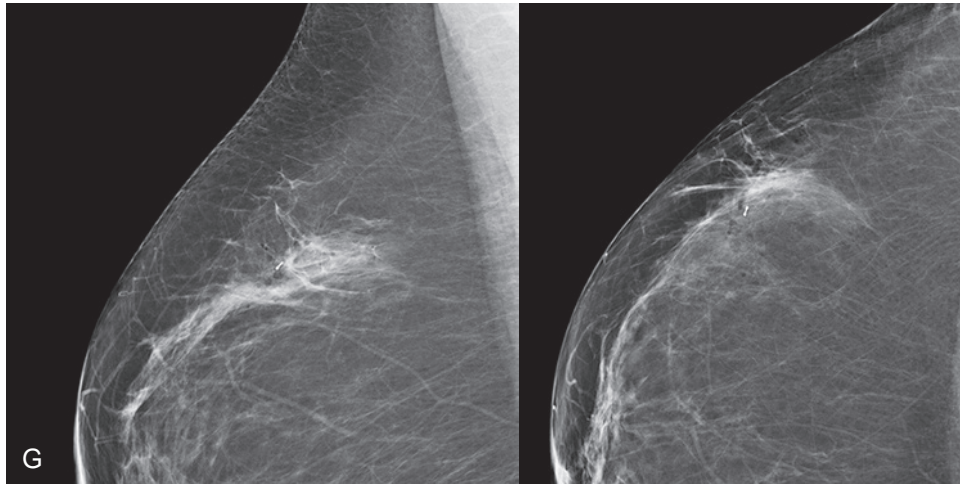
cont'd (G) Post-biopsy images show the marker in the expected area. Ultrasound core biopsy revealed infiltrating ductal carcinoma, moderately differentiated, with lymphovascular invasion, ER+/PR+/Her2-.
